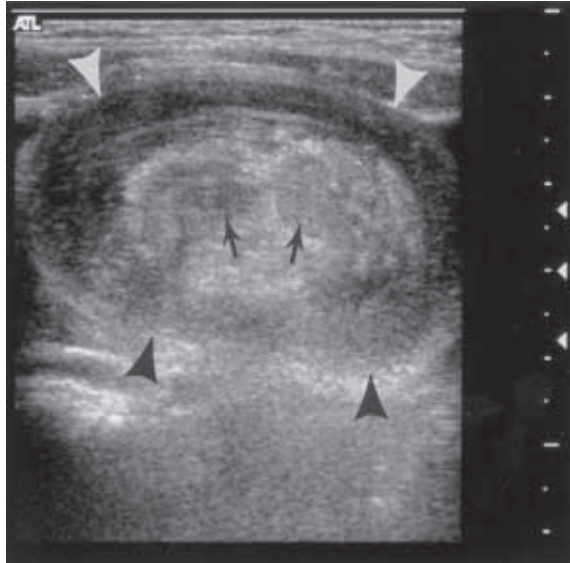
Intussusception. Sonography shows a large mass (arrowheads) with a thick hypoechoic periphery. The hyperechoic centre represents mesenteric fat with the intussusception, in this case including small lymph nodes (arrows).
